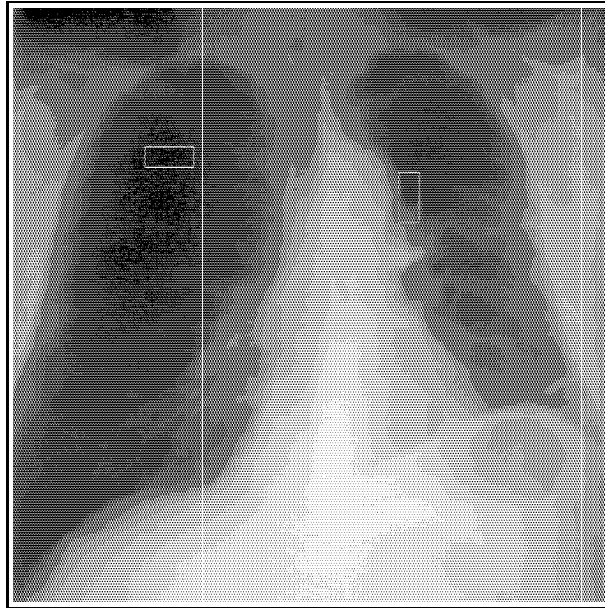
X-ray no. 8 in the series OT (after approx. 16 months after the treatment) with the regions marked: irradiated – left lung and reference – right lung.
